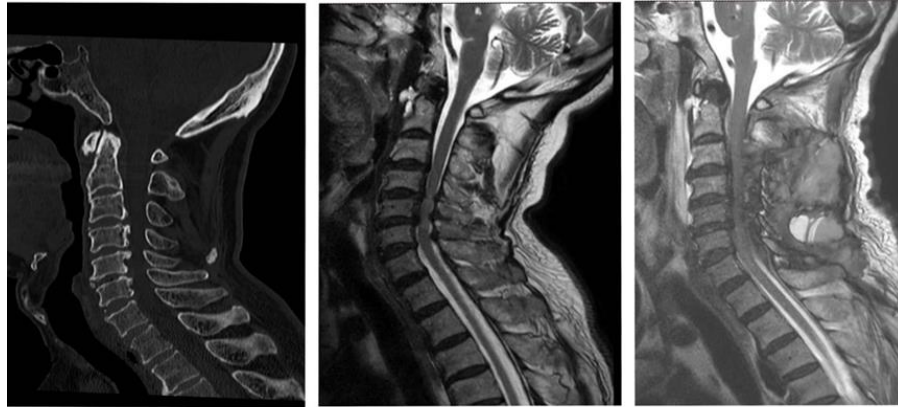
Shows example of posterior approach, images from left to right, 1: preoperative CT, 2: preoperative MRI, 3: post-operative MRI.
